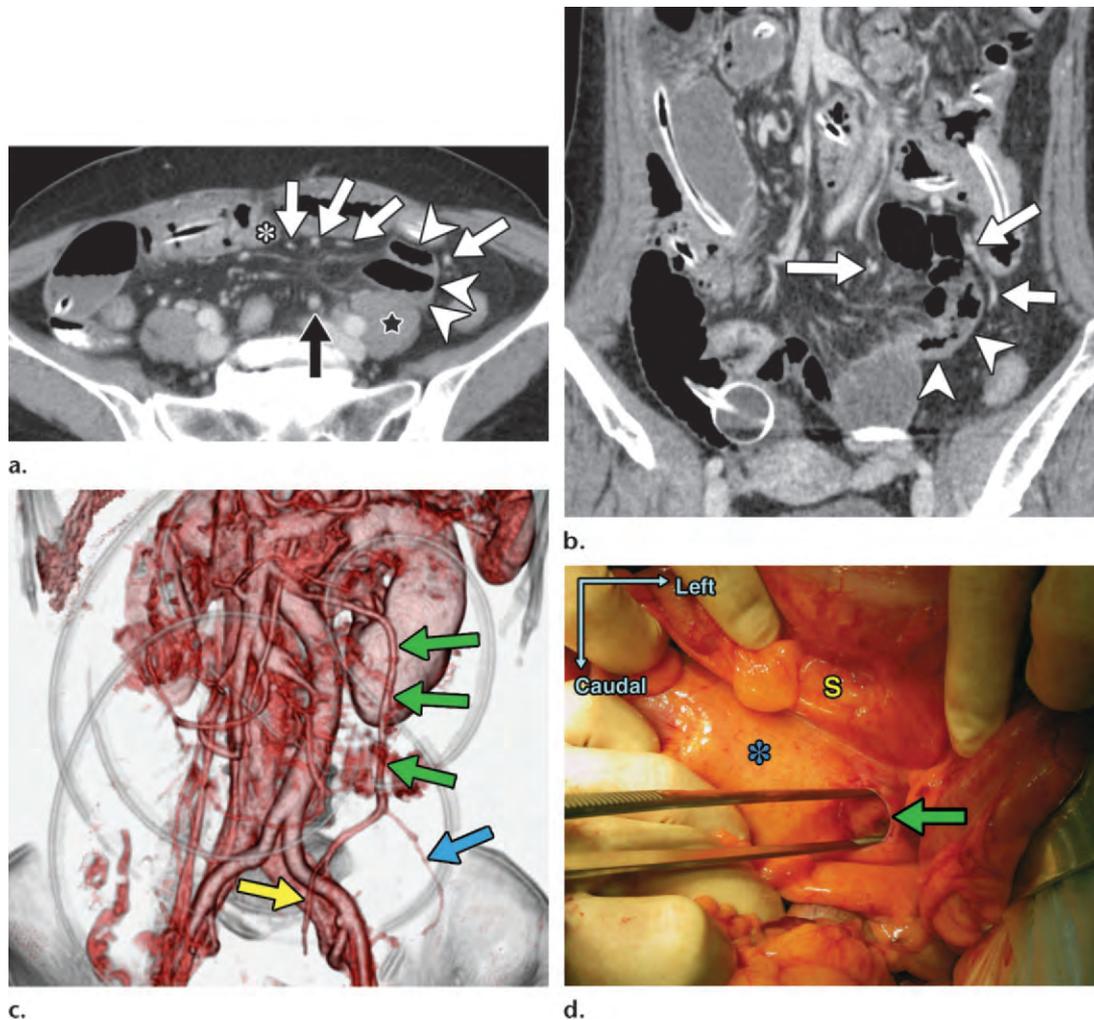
Intraesigmoid hernia in a 56-year-old woman with acute abdominal pain and vomiting. (a) Axial contrast-enhanced CT image shows incarcerated intestine within a sac (arrowheads) and enlarged, stretched mesenteric vessels in the hernia orifice between the sigmoid colon (*) and left psoas major muscle (★). The hernia orifice also separates the sigmoid vessels (white arrows) and superior rectal vessels (black arrow). (b) Coronal MPR CT image shows sigmoid and superior rectal vessels (arrows) wrapping the hernia sac (arrowheads) visually. (c) Portal venous phase 3D CT angiogram clearly depicts the separation of one of the sigmoid veins (blue arrow) and the superior rectal vein (yellow arrow). Green arrows = inferior mesenteric vein. (d) Intraoperative photograph (anterior view) after reduction shows a 2-cm-diameter defect (arrow) in only one peritoneal layer of the sigmoid mesocolon (*). The defect was surgically closed. S = sigmoid colon. (Fig 15a, 15b, and 15d adapted and reprinted, with permission, from reference 58. Fig 15c courtesy of Hironori Shigeoka, MD, Osaka Prefectural Medical Center for Respiratory and Allergic Diseases, Habikino, Japan.)
